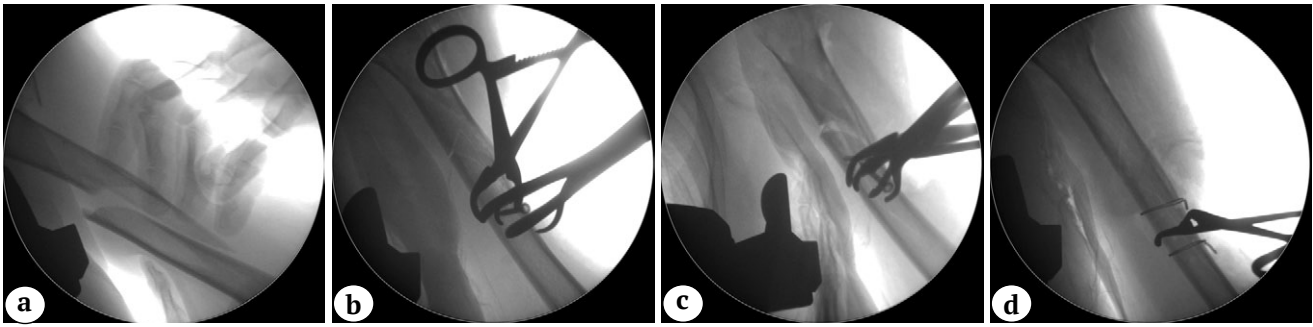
Intraoperative X-rays:
